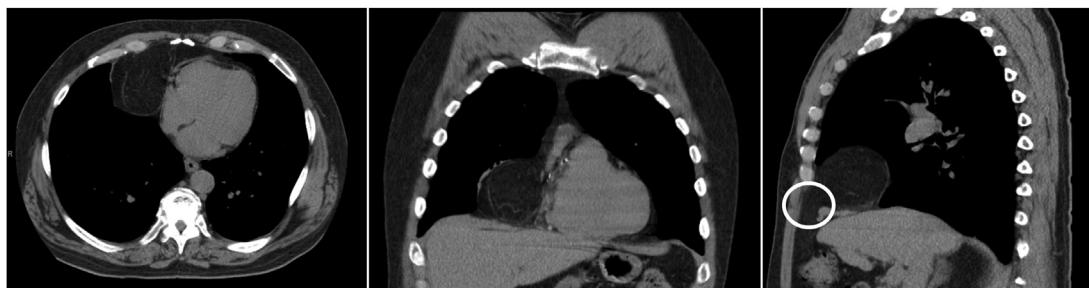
CT imaging of simple right-sided fat-containing Morgagni hernia. White circle depicts anterior hernia defect.
